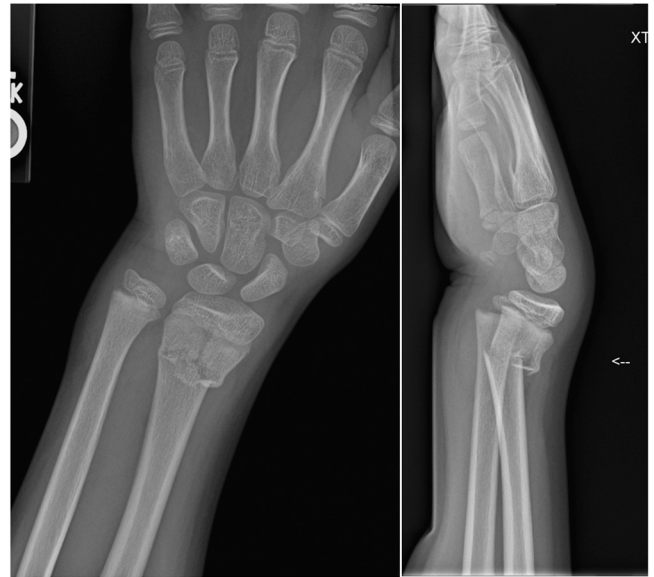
Posteroanterior (PA) and lateral wrist radiographs in an 11-year-old male after sustaining a distal radius fracture.
